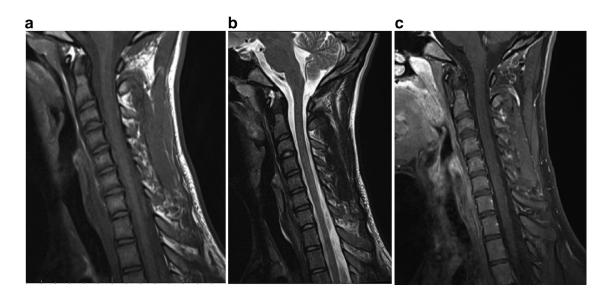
Cervical spine MRI with and without Gadolinium enhancement 3 months from diagnosis and post-systemic treatment. TSE T1 (A), T2 Dixon (B), and T1 Dixon postcontrast (C) sequences showing resolution of the initial lesion.
